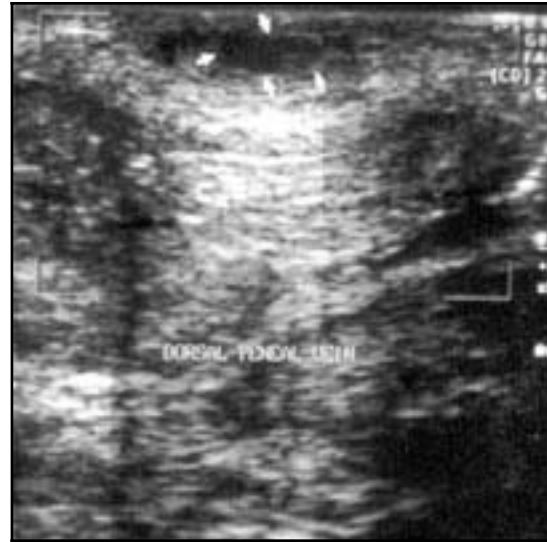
Doppler ultrasound showing thrombus in the dorsal vein of the penis.
